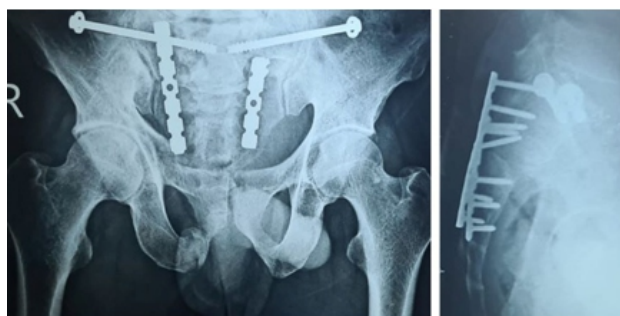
X-ray at the end of 1 year showing stable fixation.
